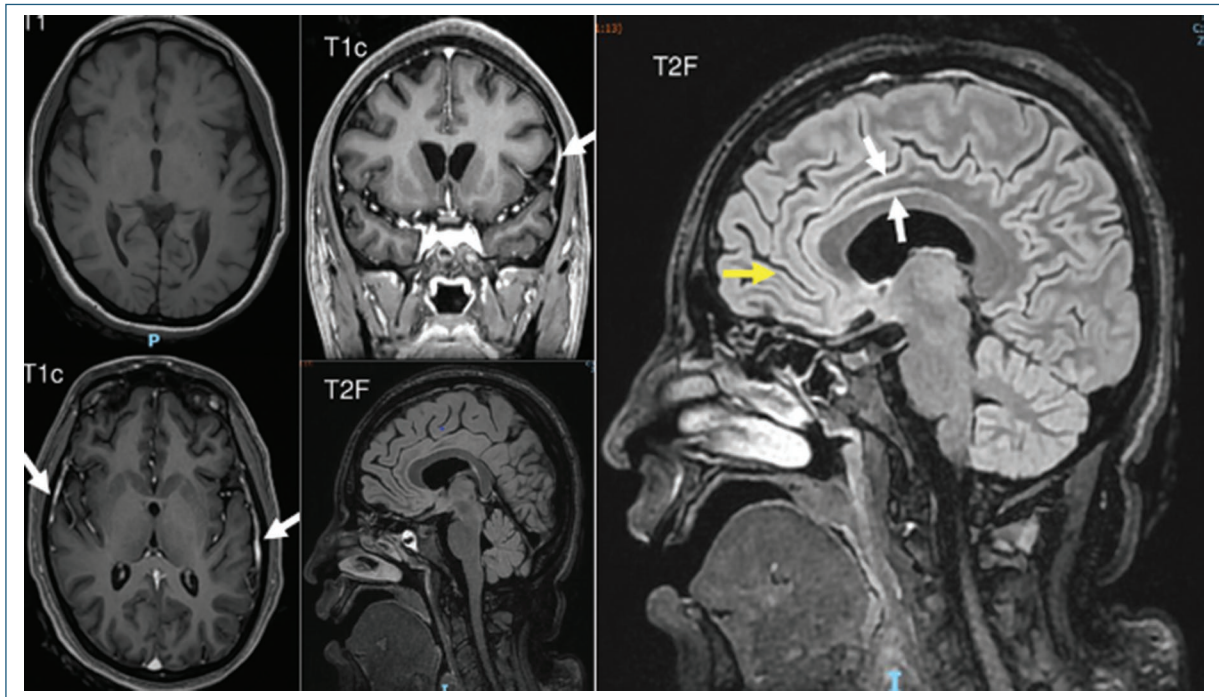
RMN. T1-weighted magnetic resonance image (MRI) showed a slight decrease in bilateral frontal cortical volume. T1c sequences showed areas of hyperintensity in coronal (top) and axial (bottom) sections of the leptomeninges; increased signal intensity was also observed in cortical gray matter in the frontomedial (yellow arrow) and bilateral anterior cingulate regions (white arrows).
